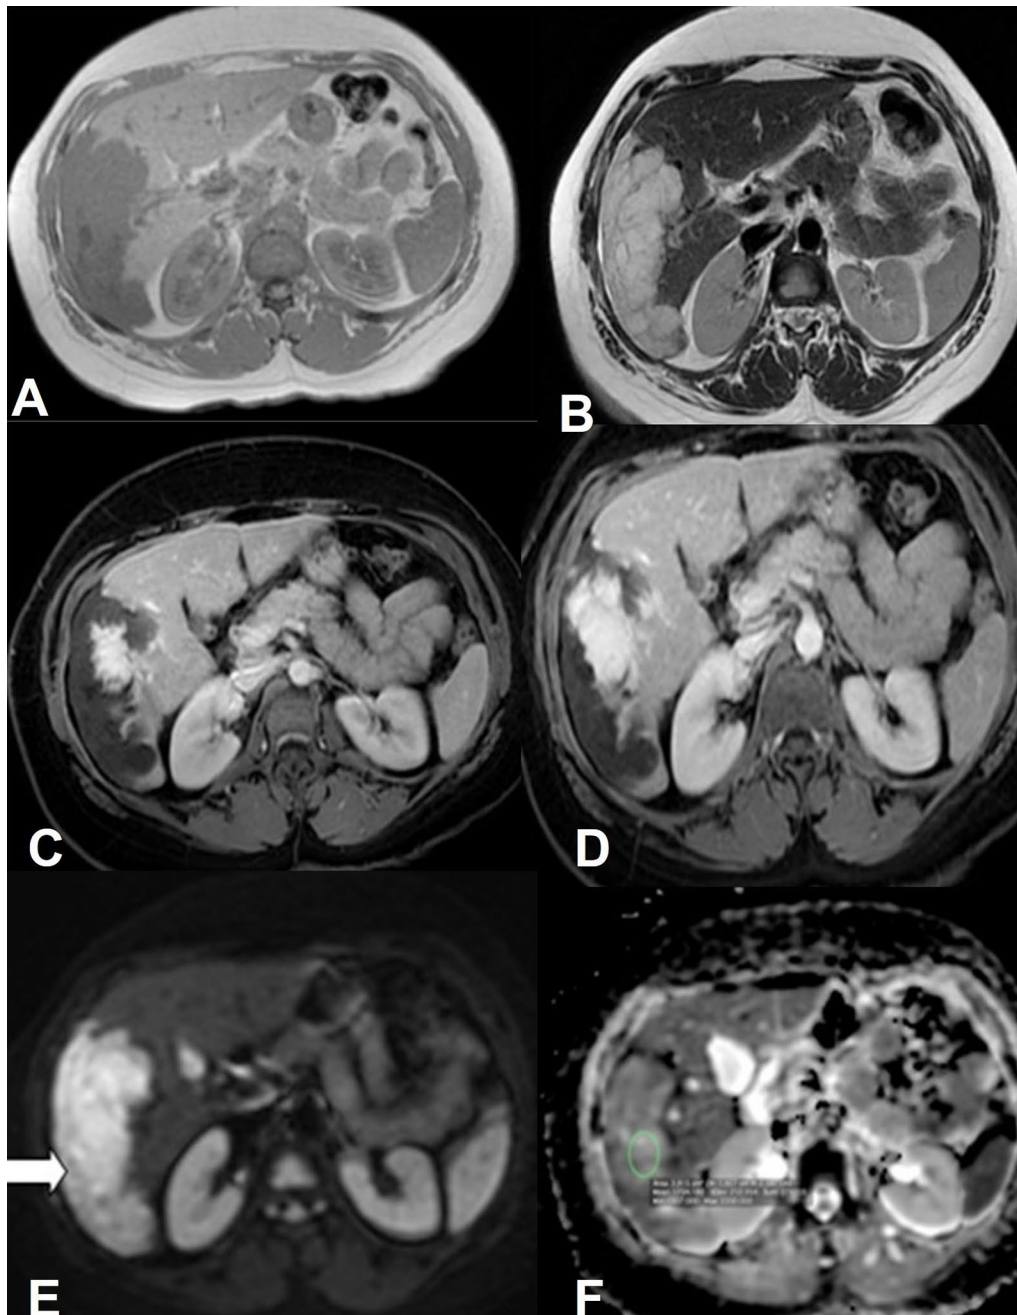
A 76-year-old male patient with high-grade CC. A Axial T1WI shows a hypointense mass lesion in segment IV of the left hepatic lobe with subtle bulge B Coronal T2WI shows a hyperintense mass lesion No biliary radicles dilatation C Arterial phase shows heterogenous peripheral arterial enhancement of the lesion, D The portovenous phase shows delayed contrast retention within the lesion, E The lesion displays high signal intensity on DWI (restricted diffusion). F The ADC value of the lesion is ( $0.9 \times 10^{-3} \text{ mm}^2/\text{s}$ )
